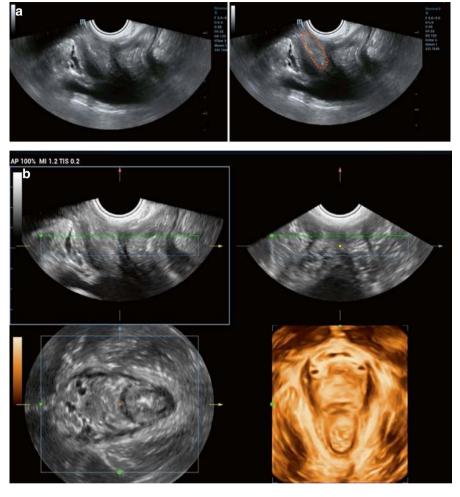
(a) Transperineal ultrasound reveals the absence of vaginal gas lines, with hypoechoic muscular structures visible. The area of vaginal atresia is circled in orange. The area of vaginal atresia is circled in orange. (b) A 3D ultrasound image shows the absence of vaginal gas lines
